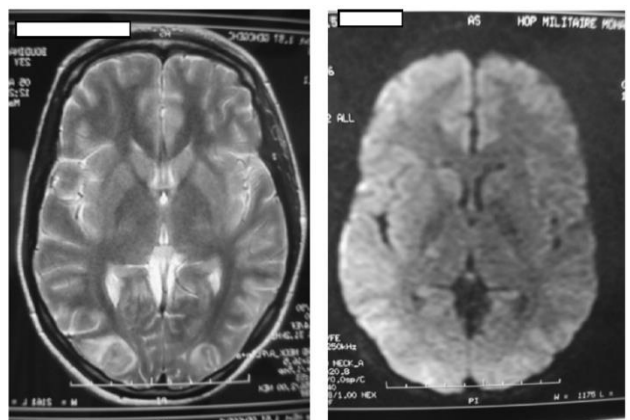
Brain MRI, axial sections, T2 and diffusion sequences: Cortico-subcortical hypersignals at bilateral occipital area, more marked on the right.
